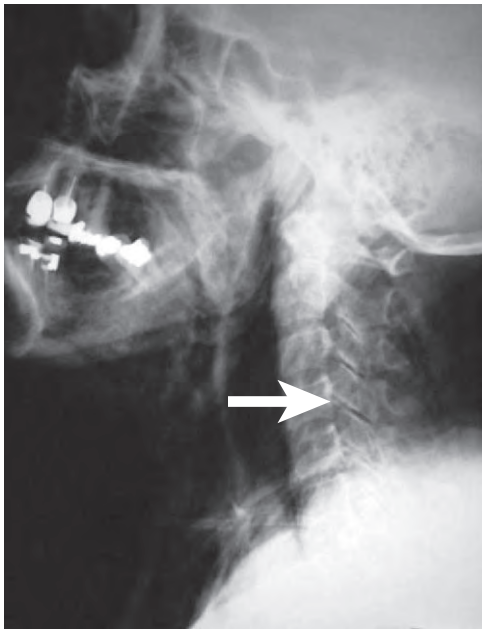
Chest roentgenogram showing air in the deep muscles of the neck after perforation of the esophagus (arrow). This is often the earliest sign of perforation and can be present without evidence of air in the mediastinum.
